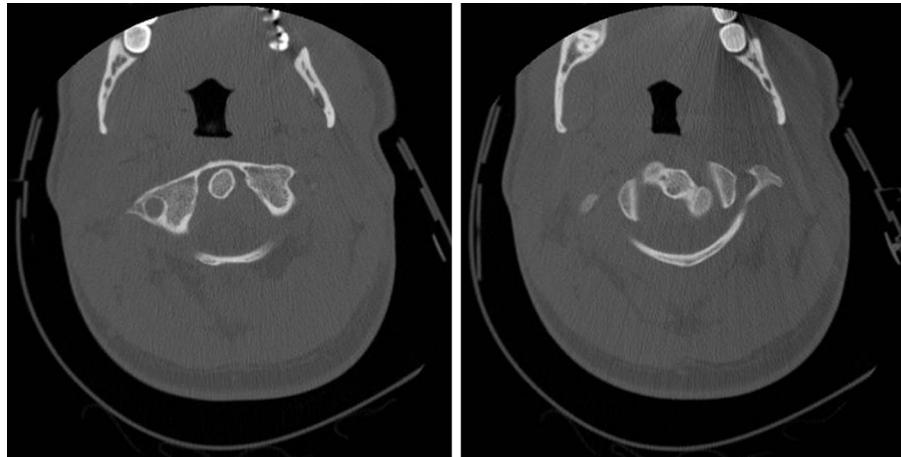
(Left) Axial computed tomography (CT) reveals anatomic positioning of the atlas with maintenance of atlantodental interval. (Right) Axial CT displays bilateral rotatory deformity/dislocation of the axis on a normally positioned atlas.
